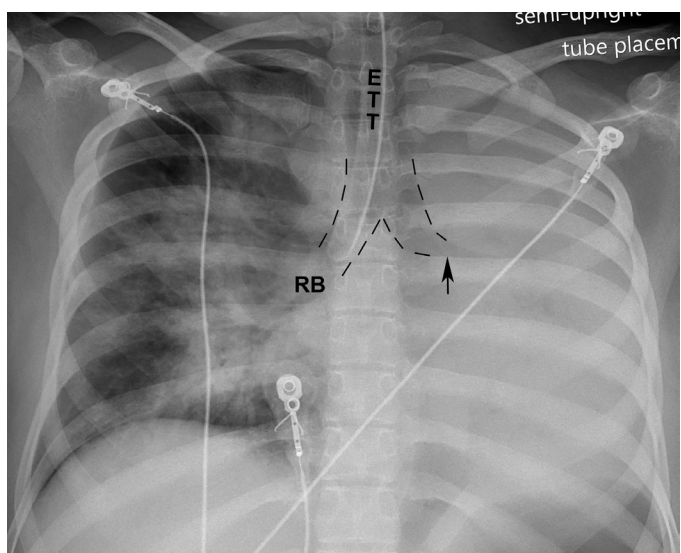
■ Anteroposterior (AP) chest x-ray. Right main stem bronchus intubation with the collapse of the entire left lung and leftward shift of the mediastinum. In this case, the left hemidiaphragm and left ventricular border are no longer seen. The “collapse” is always opposite the side that is selectively intubated. Right perihilar air space opacities are due to “batwing” edema caused by acute myocardial infarction. Arrow marks the “cutoff” sign. ETT, endotracheal tube; RB, right main stem bronchus.
